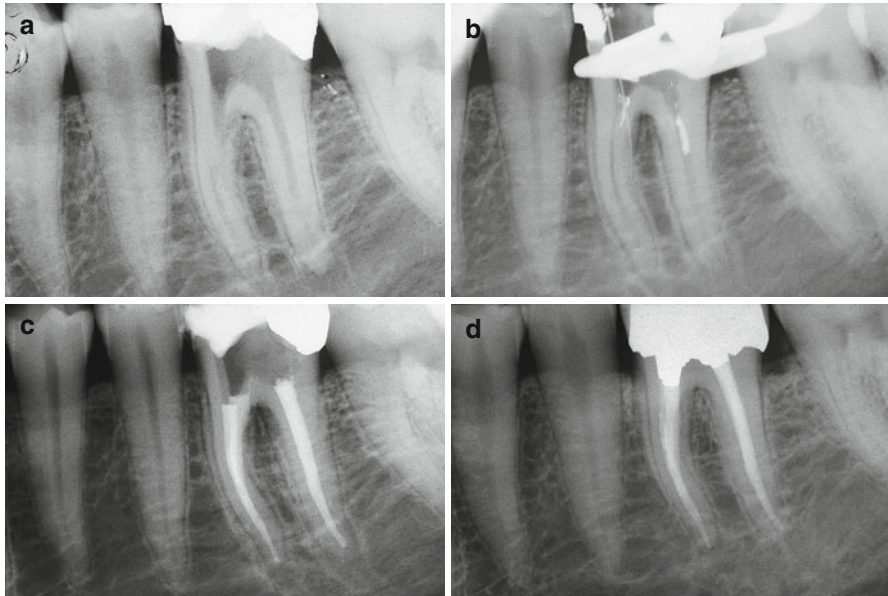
In an attempt to find the mesiobuccal canal, a perforation was made in the floor of the pulp chamber. (a) Preoperative radiograph. (b) A small file has been introduced in the bleeding area and has been connected to an electronic apex locator to confirm the diagnosis of a perforation. (c) Postoperative radiograph. The coronal portion of the mesial canal has been filled with MTA before obturating the apical part with warm gutta-percha. (d) 2-year recall
